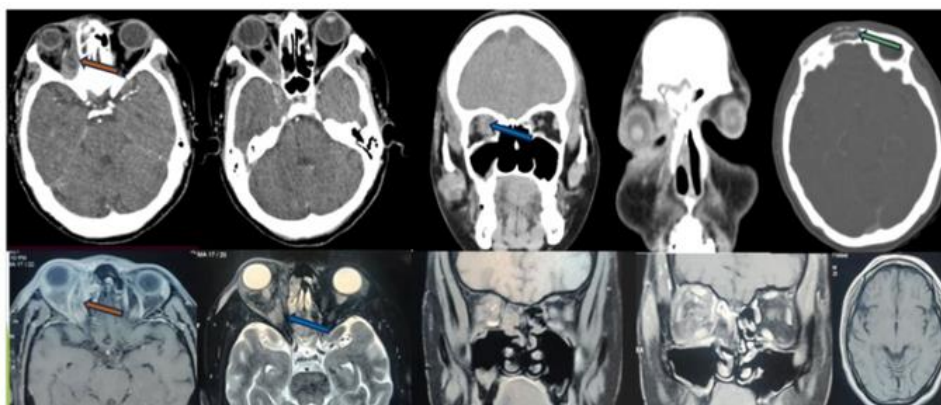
Plain and contrast CT showing peripherally enhancing collection (Orange arrow) along medial wall of right orbit extending into apex (Blue arrow). There are also osteomyelitis changes of frontal bone on right side (green arrow). T1 contrast and T2 FS images showing peripherally enhancing collection along medial wall extending into apex with fat stranding Axial T1 showing no bony changes.
